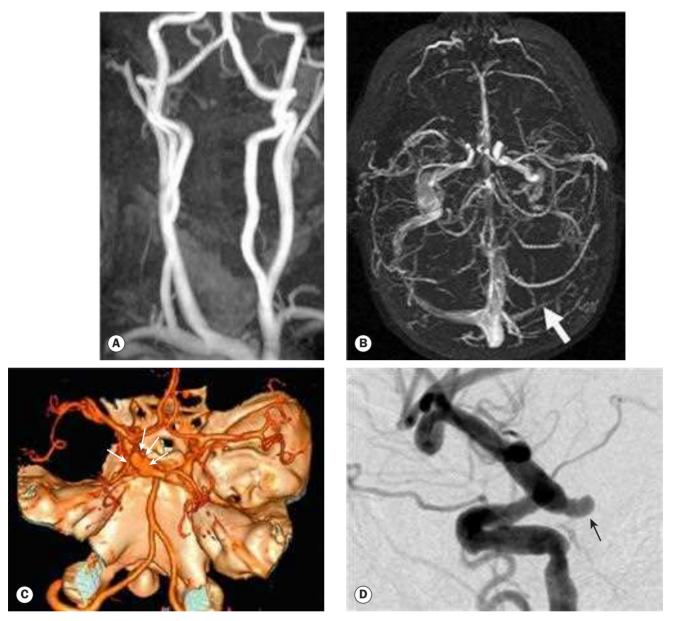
Cerebral angiography. (A) Normal MRA of the external carotid and vertebral circulation; (B) MRI venogram, axial view, demonstrating narrowing of the left transverse sinus (arrow) in idiopathic intracranial hypertension; (C) CT angiogram showing a left posterior communicating aneurysm (arrows); (D) conventional catheter angiogram with subtraction showing an aneurysm arising from the internal carotid artery at its junction with the posterior communicating artery (arrow)
